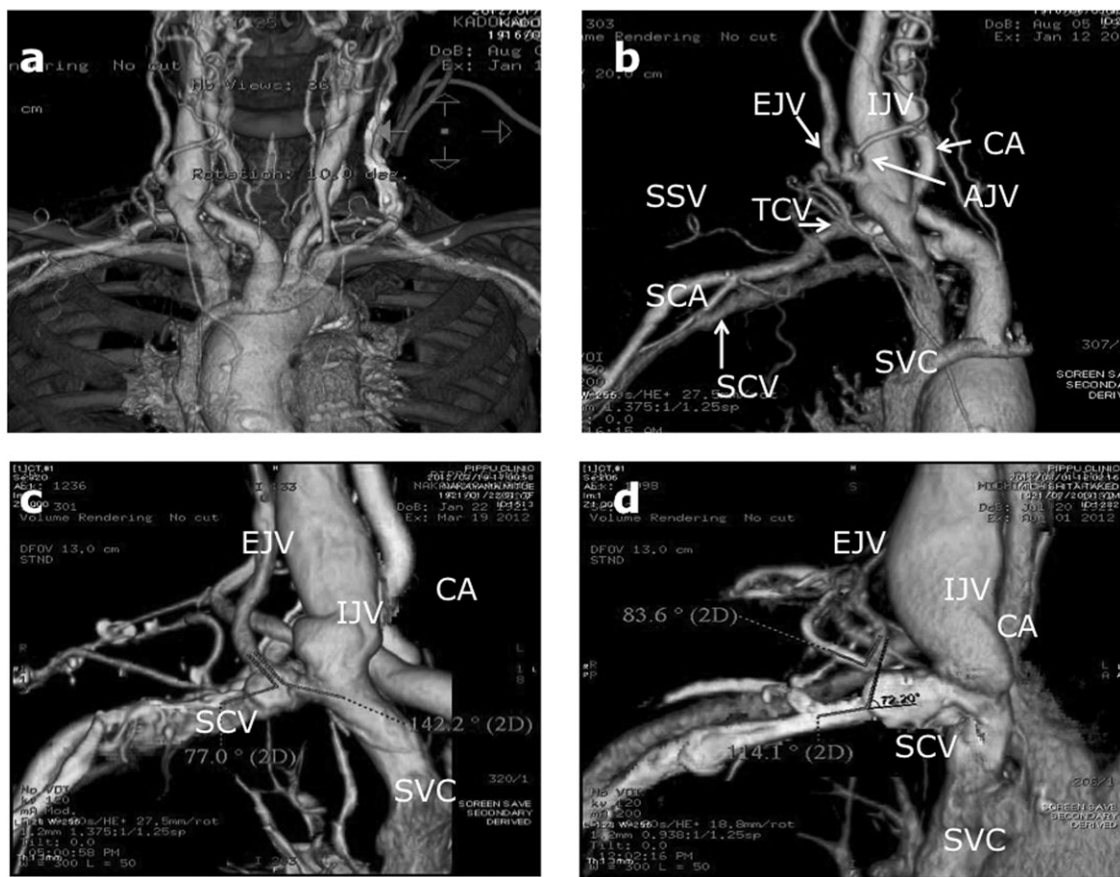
(a and b) MDCT venography of the cervical venous plexus: anteroposterior (AP) and lateral volume-rendered (VR) images. The CT-V showed a detailed cervical venous plexus and the central venous system. The CT-V clearly revealed individual vascular anatomies around the EJV and SCV junction. EJV, external jugular vein; IJV, internal jugular vein; CA, carotid artery; AJV, anterior jugular vein; TCV, transverse cervical vein; SSV, supraclavicular vein; SCA, subclavian artery; SCV, subclavian vein; SVC superior vena cava; AA, aortic arch. The CT-V showed the angle between the left EJV and the right SCV. The mean angulation between the right EJV and the right SCV measured 144 ± 36 degrees in the obtuse-angle cases (c) and 72 ± 28 degrees in the sharp-angle cases (d).
